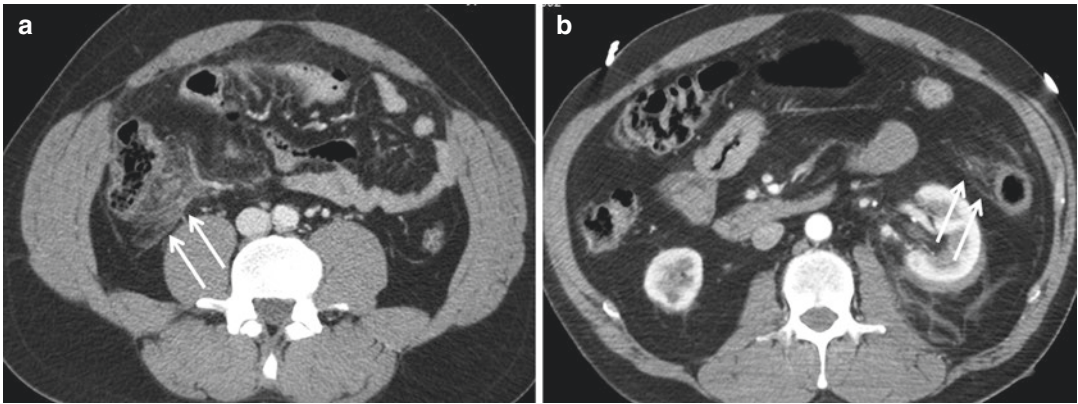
Mesenteric stranding, appearing as ill-defined, striated soft-tissue infiltration of pericecal fat (*arrows in a*) and left paracolic gutter (*arrows in b*) on axial CT contrast-enhanced scans
